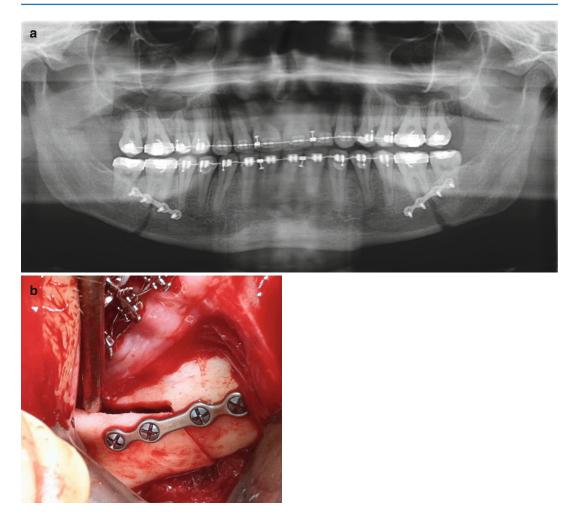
(a) Panoramic radiograph demonstrating monocortical plate and screw fixation following SSRO surgery. (b) Intraoperative view of monocortical plate and screw
